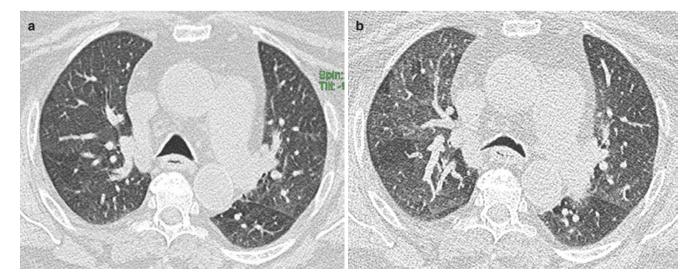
Tracheobronchomalacia with air-trapping. (a) Inspiratory and (b) expiratory CT images show air-trapping. Note "Frown" sign
